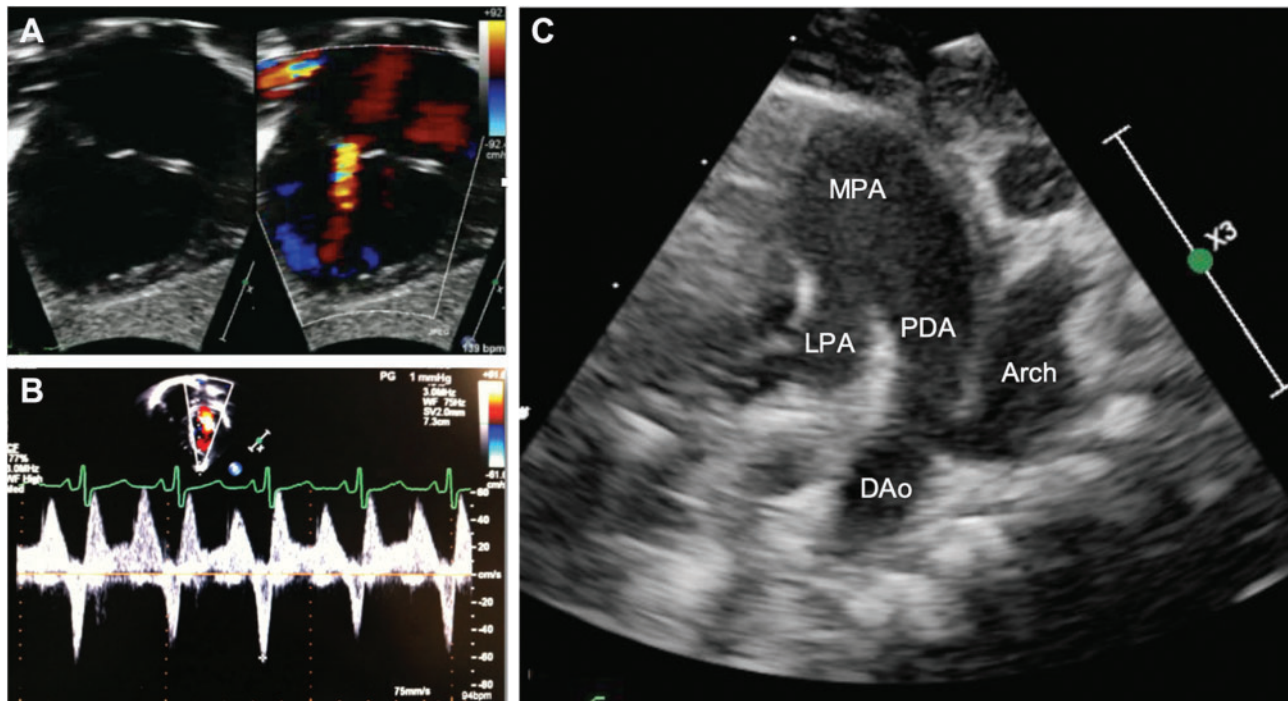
Life-maintaining structures. Small restrictive foramen ovale (A) with significant A-wave reversal on pulmonary vein Doppler scan (B). Large DA with coarctation of the aorta (C). DA: ductus arteriosus; DAo: descending aorta; LPA: left pulmonary artery; MPA: main pulmonary artery; PDA: patent DA.
